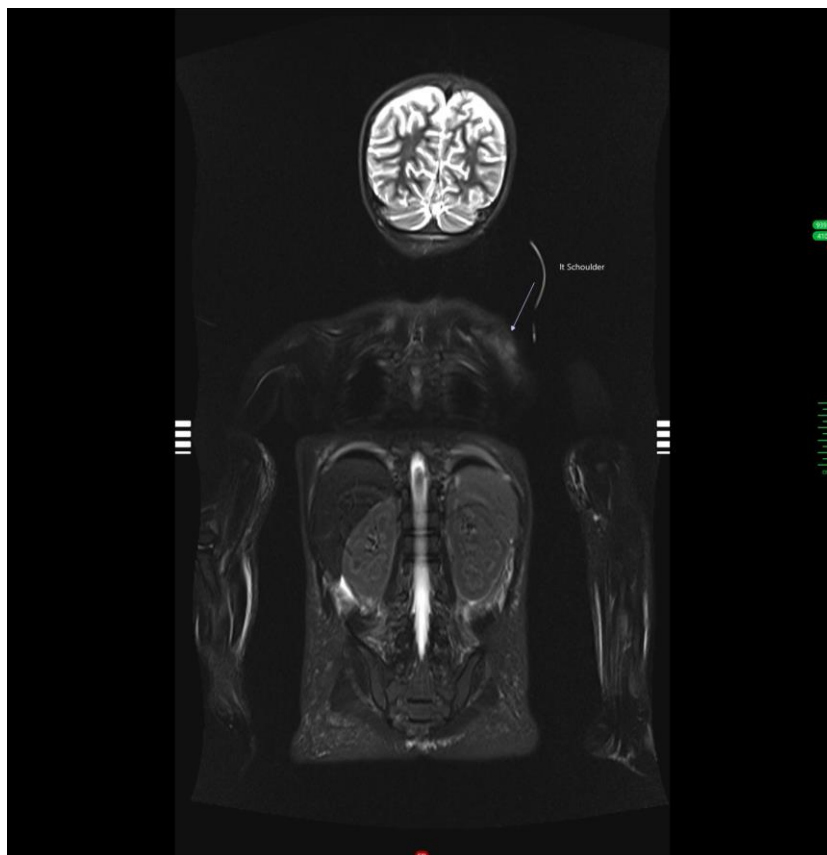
MRI finding: Left shoulder increased muscular signal intensity indicating myositis
